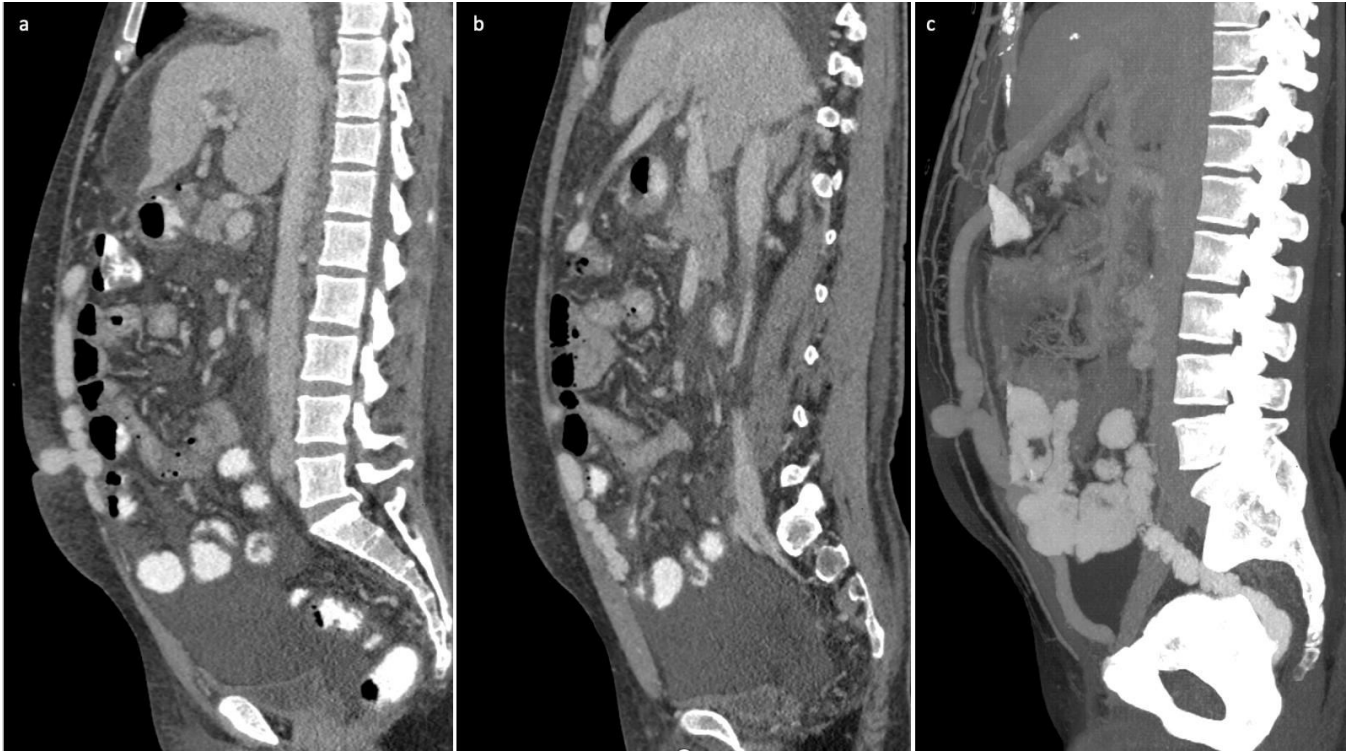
& Figure 7b Sagittal CT abdomen post contrast images reveal nodular liver surface, ascites and herniated left paraumbilical vein through anterior abdominal wall defect in umbilical region.
